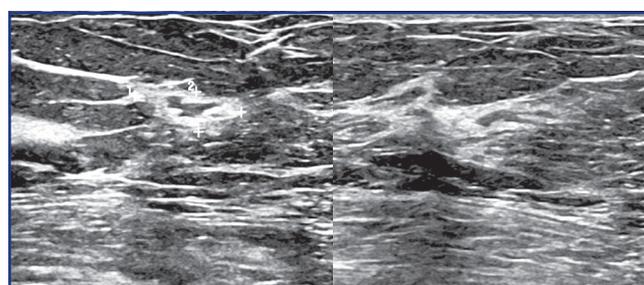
Ultrasound examination of the right mammary gland: a neoplasm, irregular shaped
